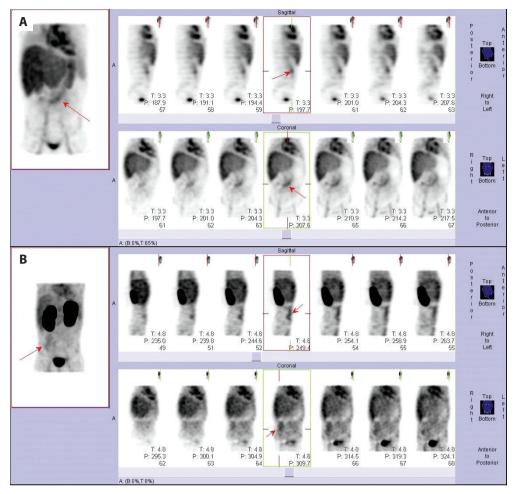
A. Technetium 99m-labeled human serum albumin scintigraphy (the arrows show leakage of albumin in the region of the small intestine). B. Technetium 99m-labeled erythrocytes scintigraphy, the arrows show leakage of erythrocyte in the region of the small intestine
